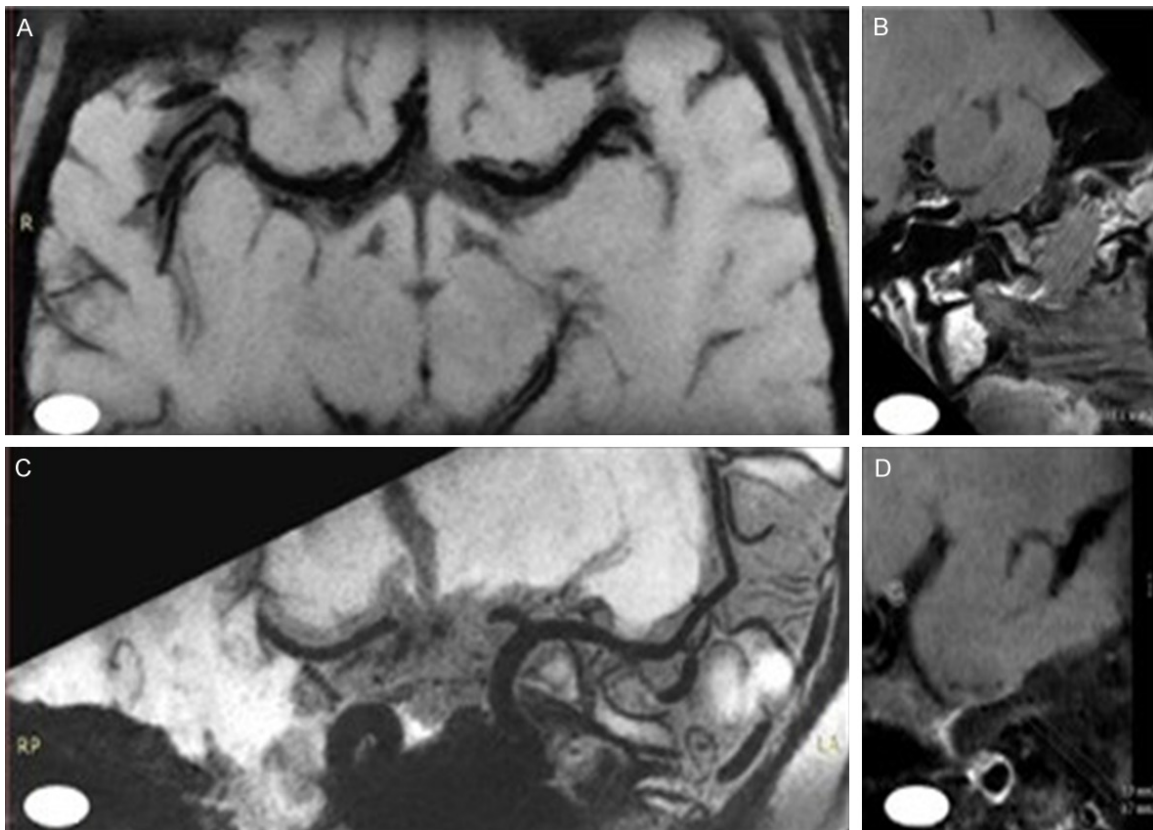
CE-T1WI multiplanar reconstruction. A: The vascular wall and lumen can be clearly seen in the axial direction of CE-T1WI; B: Vascular area; C: The oblique position of CE-T1WI can clearly see the vessel wall and lumen; D: The vascular area and the lumen area on the sagittal plane of the largest stenosis. CE-T1WI: contrast-enhanced T1-weighted imaging.
